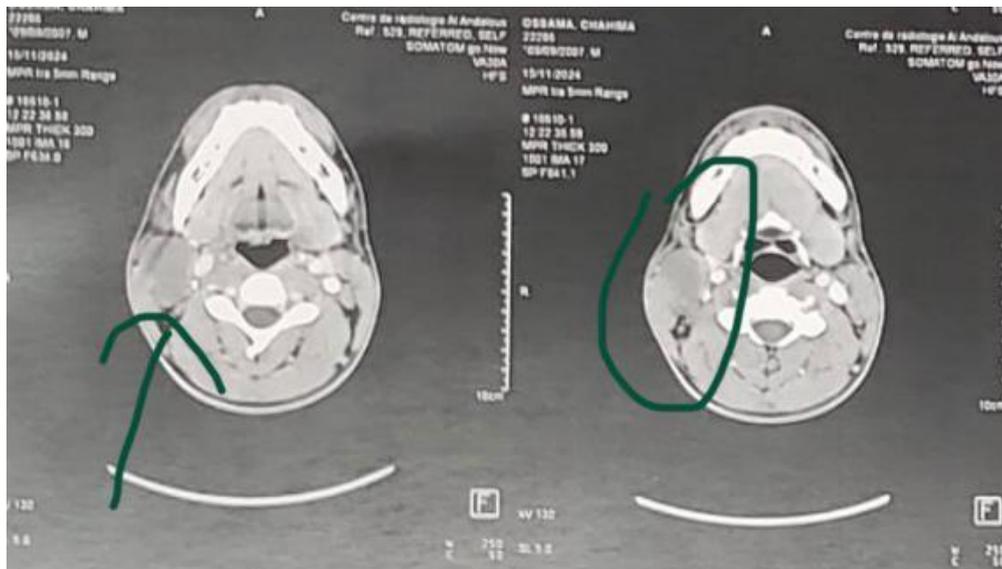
Axial sections of the cervico-facial CT scan in parenchymal windows showing the latero-cervical mass
